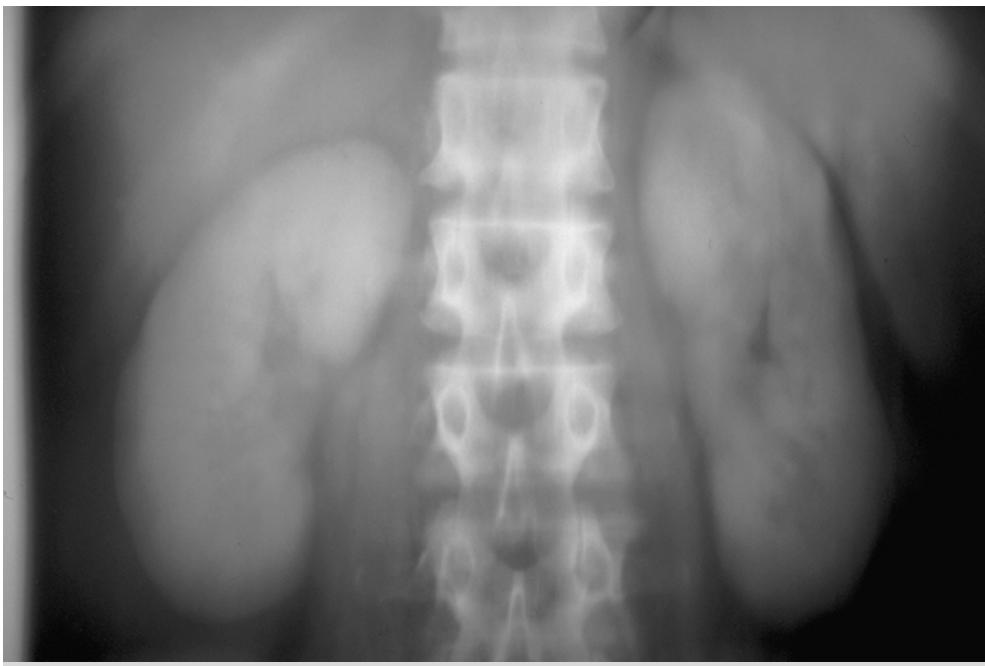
The nephrogenic phase is captured on this radiographic image after intravenous injection of contrast.
